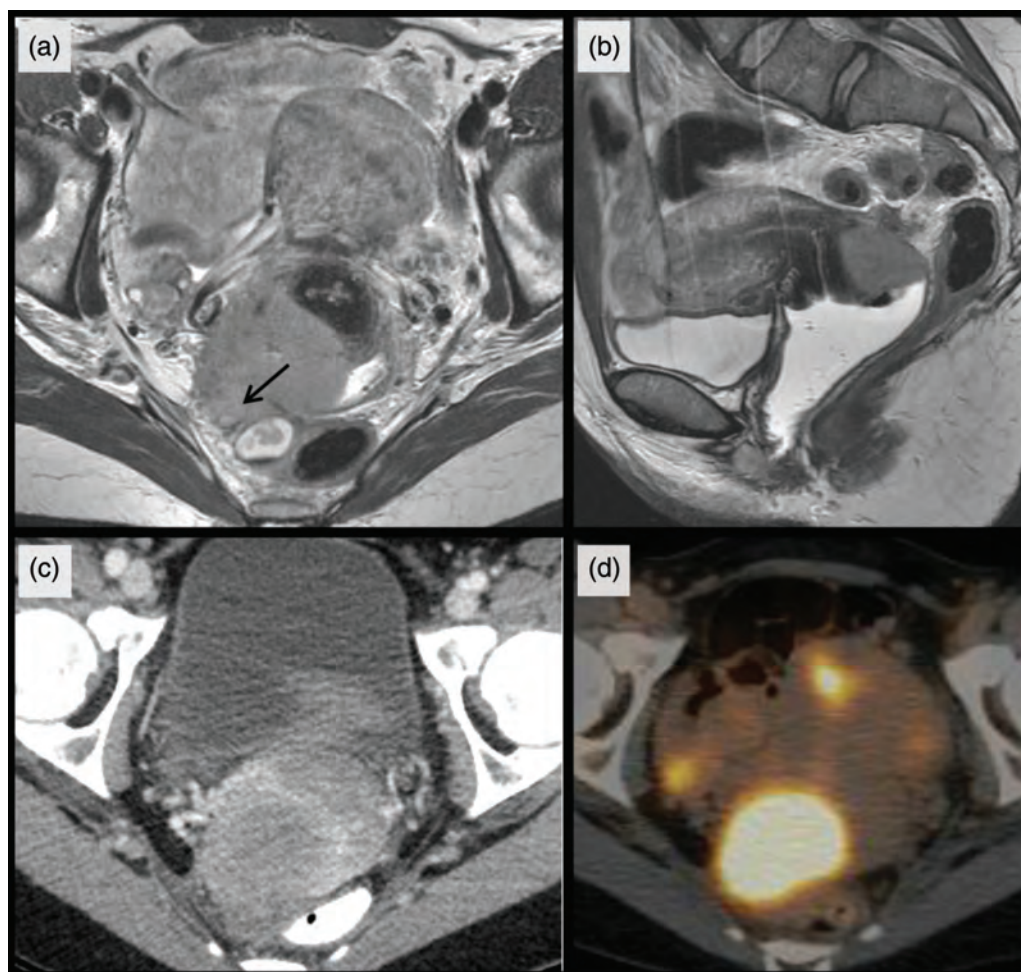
Axial MRI (a), sagittal MRI (b), CT (c), and FDG PET (d) showing a large cervical mass with extension toward the right parametrium (black arrow) and close to the rectum along the right utero-sacral ligament.
